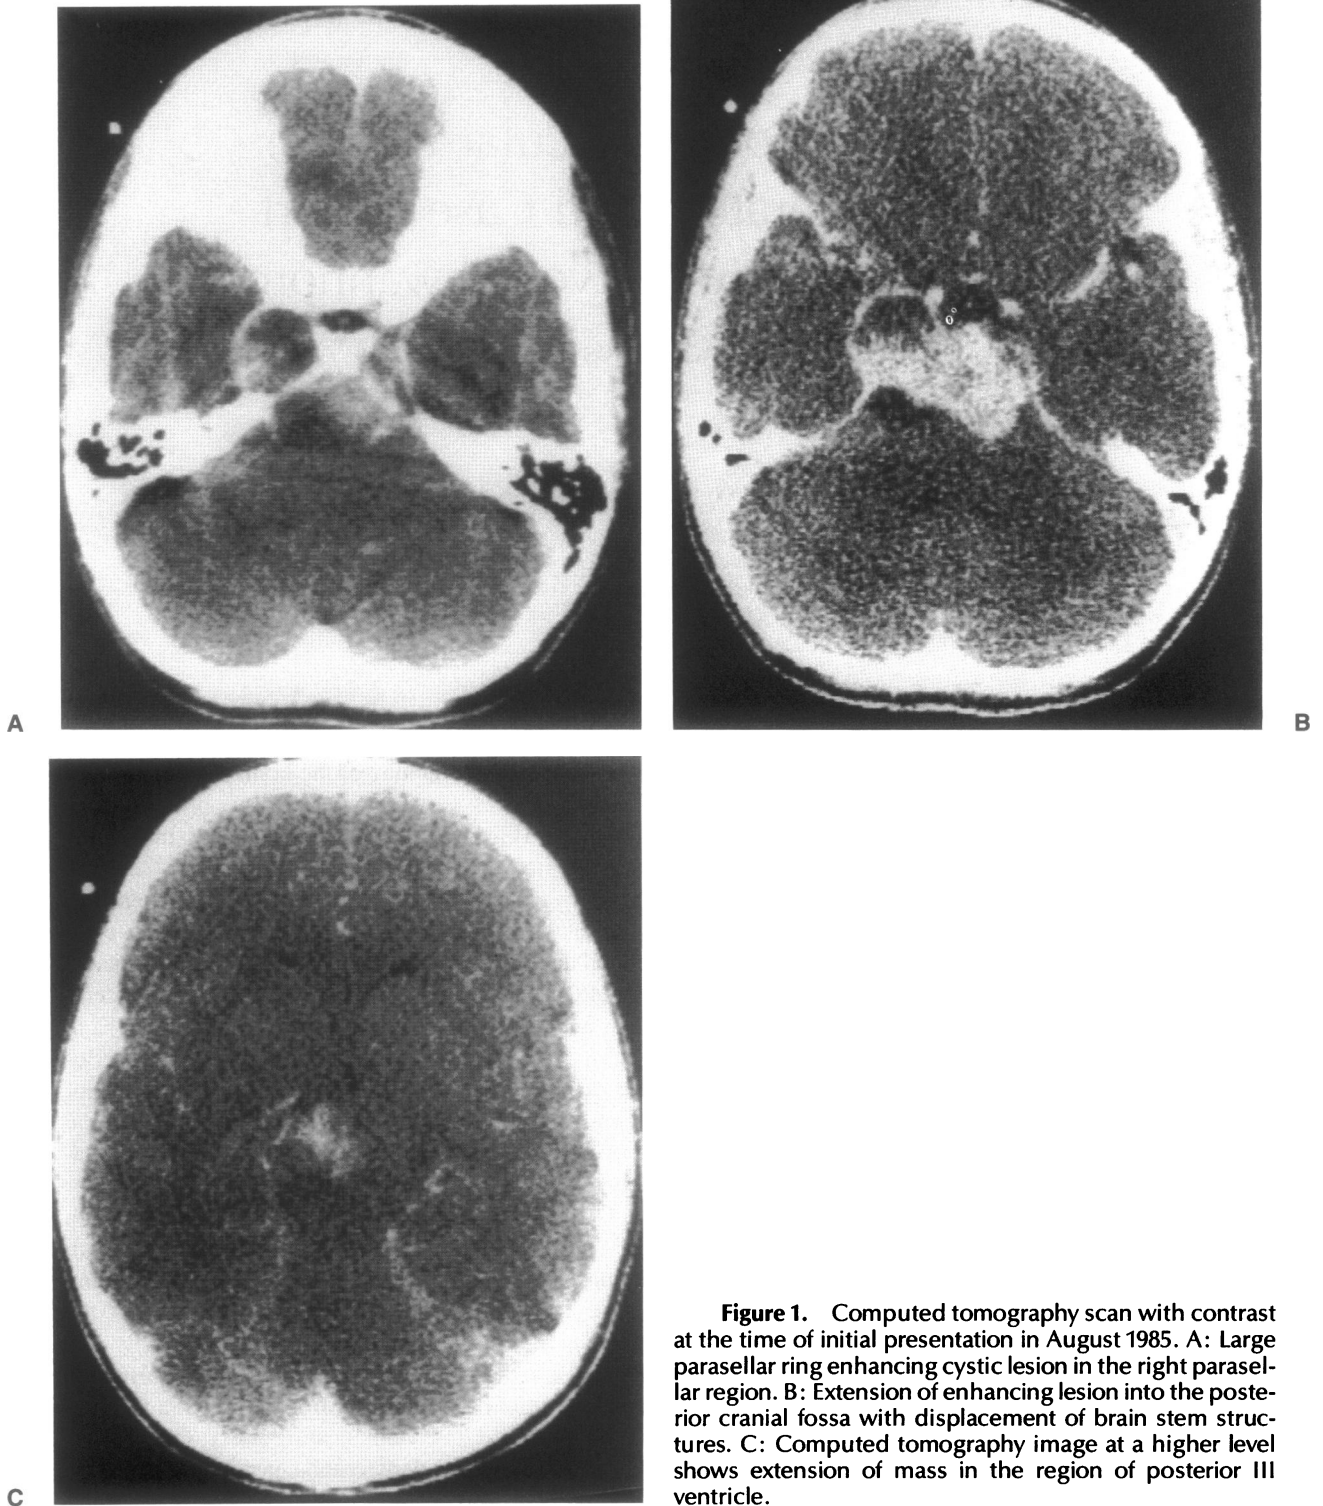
Computed tomography scan with contrast at the time of initial presentation in August 1985. A: Large parasellar ring enhancing cystic lesion in the right parasellar region. B: Extension of enhancing lesion into the posterior cranial fossa with displacement of brain stem structures. C: Computed tomography image at a higher level shows extension of mass in the region of posterior III ventricle.
